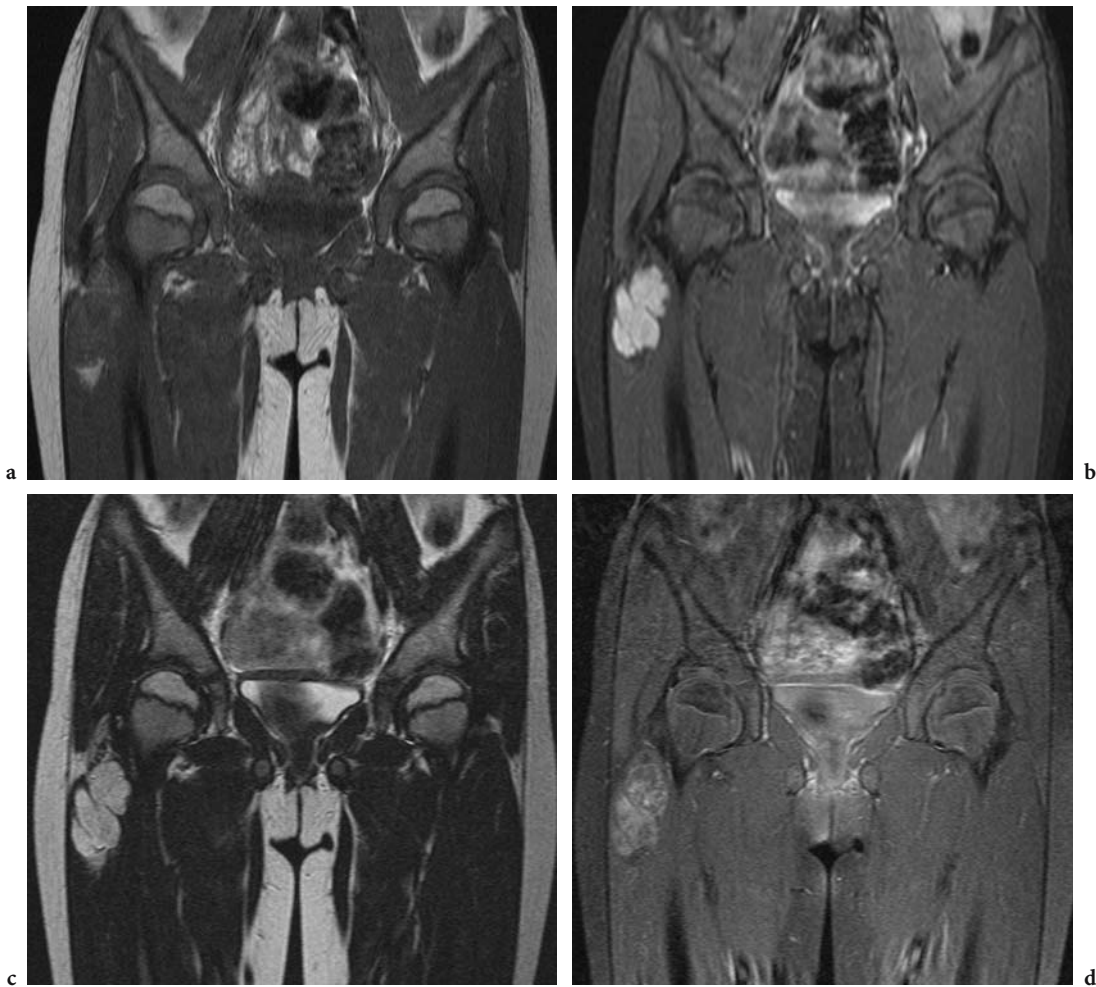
a Coronal T1-weighted MRI shows a slightly hyperintense mass in the right quadriceps. b In short time inversion recovery (STIR) sequence, the well-delineated mass is hyperintense. c In T2-weighted image, the lesion remains hyperintense to the muscle. d Coronal T1-weighted scan after gadolinium injection and fat saturation shows slight and heterogeneous enhancement
